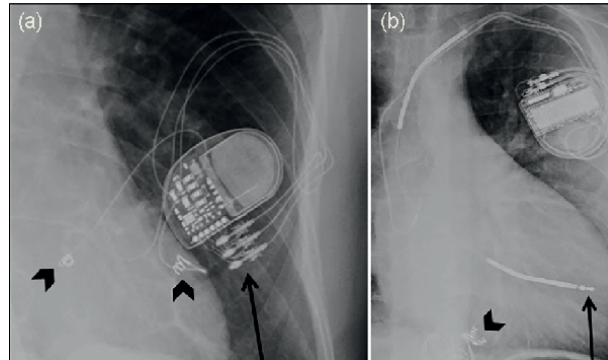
(a) Chest X-ray ensuring lead placement in pacemaker is correct, and (b) ICD segmented coils being shown (Torres-Ayala et al. [37]).
